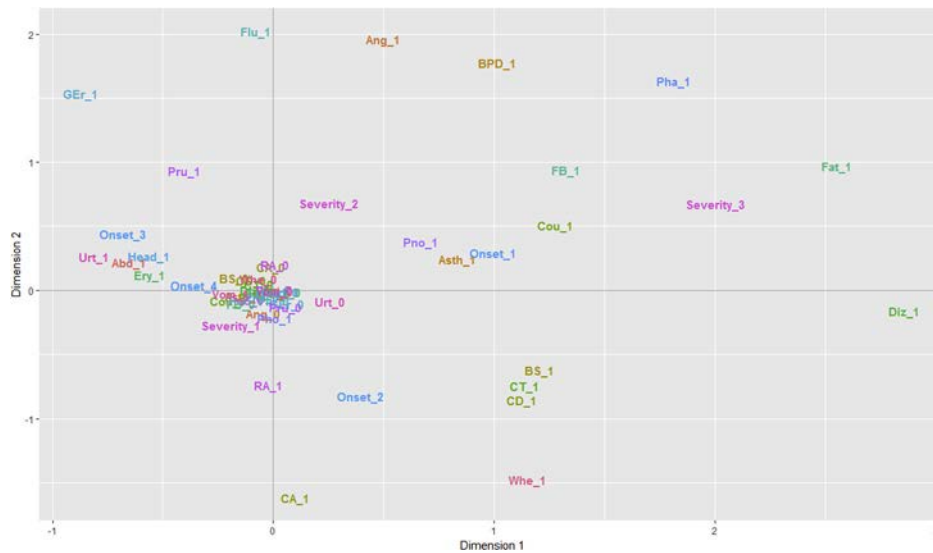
MCA representation: *ABD*, Abdominal pain; *ANG*, angioedema; *ASTH*, asthma; *BPD*, blood pressure; *BS*, bronchospasm; *CA*, conjunctivitis; *CD*, chest discomfort; *COU*, cough; *CT*, chest tightness; *DIA*, diarrhea; *DIZ*, dizziness; *ERY*, erythema; *FAT*, fatigue; *FB*, sensation of foreign body; *FLU*, flushing; *GER*, generalized erythema; *HEAD*, headache; *HYP*, hypotension; *LARY*, laryngeal edema; *LOC*, loss of conscience; *NAU*, nausea; *Onset_1*, SAR in the first 15 minutes; *Onset_2*, SAR between 16 and 30 minutes; *Onset_3*, SAR between 31 and 120 minutes; *Onset_4*, SAR later than 121 minutes; *PHA*, dysphagia; *PHO*, dysphonia; *PNO*, dyspnea; *PRU*, pruritus; *Severity_1*, *Severity_2*, *Severity_3*, according to EASSI’s doctors; *SYN*, syncope; *TAC*, tachycardia; *UR*, urticaria; *VOM*, vomiting; *WHE*, wheezing; *1*, present; *0*, absent.
